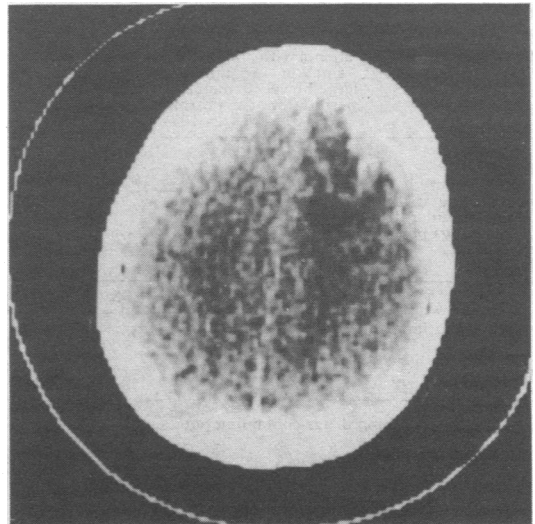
Computed tomogram (case 1) showing right frontal haemorrhagic infarction.
